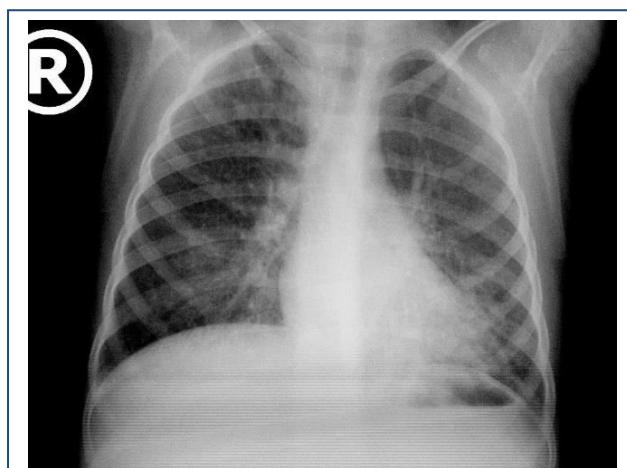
Initial X-ray of the patient (age 6 years and 11 months) – signs for bronchial obstruction in the right and multiple bilateral fibrosis changes.
